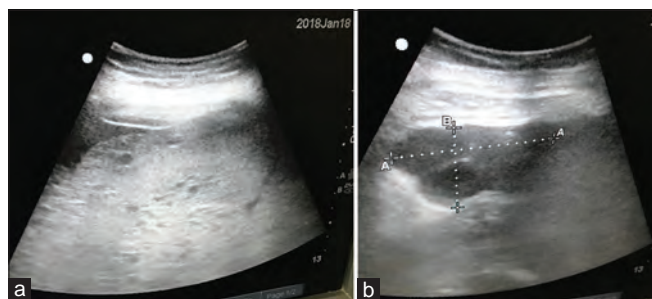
(a) Ultrasonography image showing grossly enlarged uterus with heteroechoic area with multiple variable size cysts with no evidence of fetal tissue, suggestive of complete hydatidiform mole. (b) Ultrasonography image showing enlarged left ovary with cyst of size 5.5 \times 2.3 cm suggestive of theca lutein cyst
